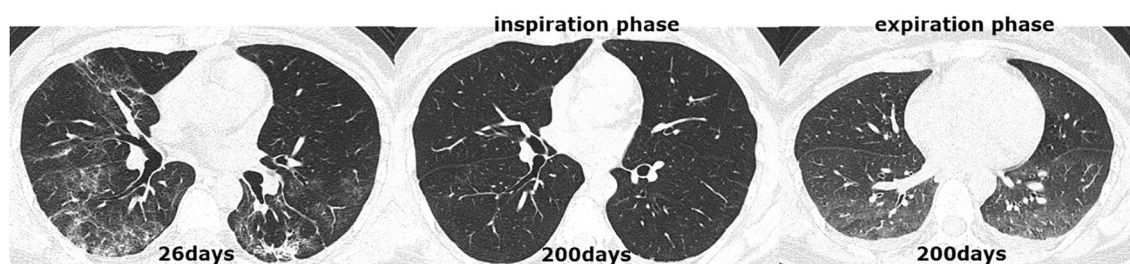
CT scan series in a 40-year-old COVID-19 patient with abnormal DL_{CO} (74.6%) at the 6-month follow-up. (a) Transverse CT scan obtained 26 days after the onset of symptoms showed diffuse ground-glass opacities coexisting with consolidations in both lungs. (b) Scan obtained during full inspiration on day 200 demonstrated complete resolution of lung abnormalities. (c) Scan obtained during expiration at 200 days showed substantial air trapping.
